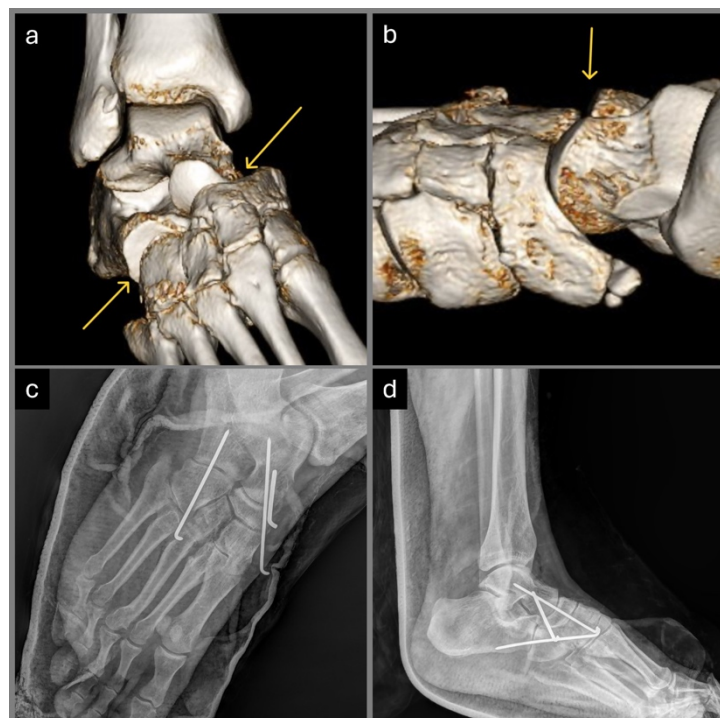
Imaging diagnostics of Case 2 patient: three-dimensional computed tomography shows plantar dislocation of the Chopart joint (yellow arrows) (a, b); postoperative X-rays (white lines indicate K-wires) (c, d).
